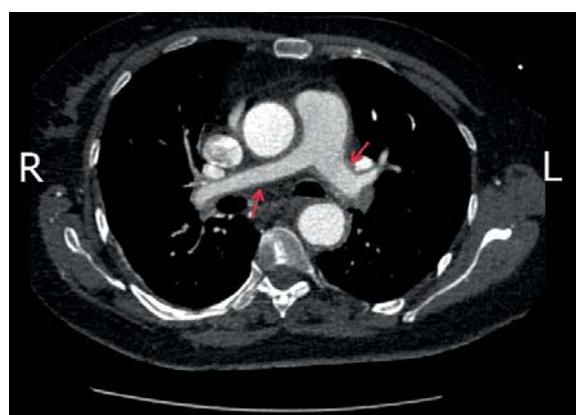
CT scan of the pulmonary trunk and large proximal branches (axial plane). Wall thickening of the pulmonary arteries (5 mm) owing to inflammation. Narrowing of the left and right pulmonary arteries, 12 mm and 10 mm respectively (red arrows)
